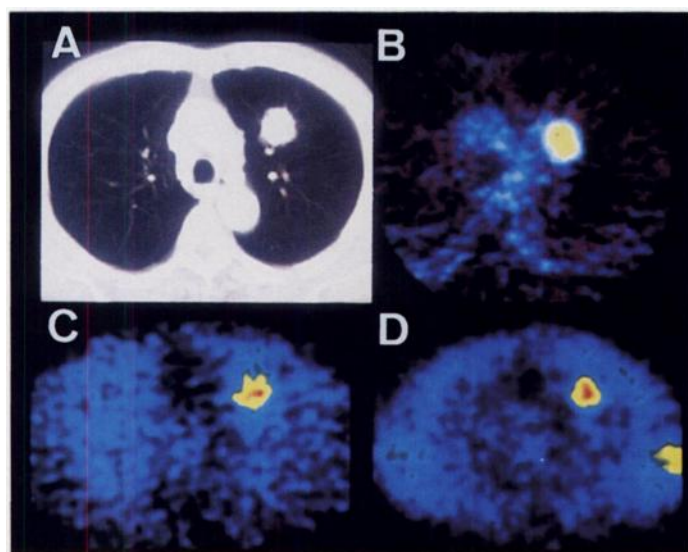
Patient 26, squamous cell carcinoma, 3.0 × 3.0 × 3.0 cm, pT1N0M0. (A) CT image shows nodule in the left lung. (B) FDG PET shows significantly hot accumulation in the tumor (SUV, 7.22; T-to-N ratio, 12.9). (C) Early scan on Tl SPECT. (D) Delayed scan on Tl SPECT. Tl SPECT also reveals good visualization of the tumor (ER, 2.91; DR, 4.79; RI, 64.6%).
